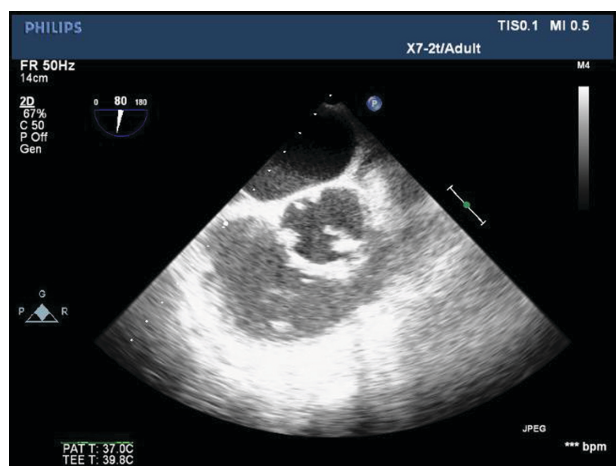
Intraoperative echocardiogram in the parasternal short axis view at 80 degrees, showing the ruptured non-coronary cusp.
